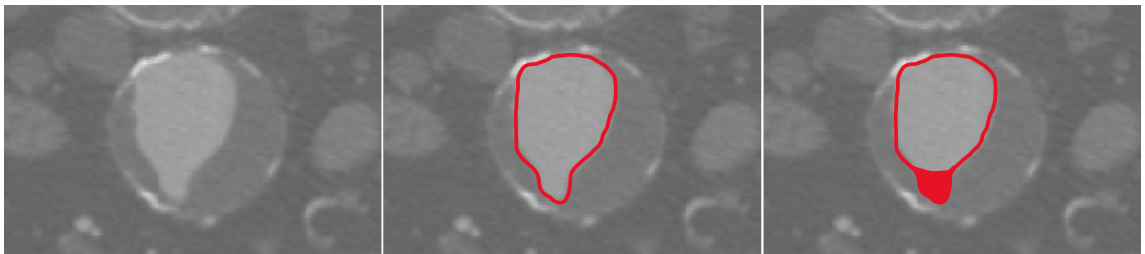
CTA slice of an AAA with thrombus occluding the lumen.
